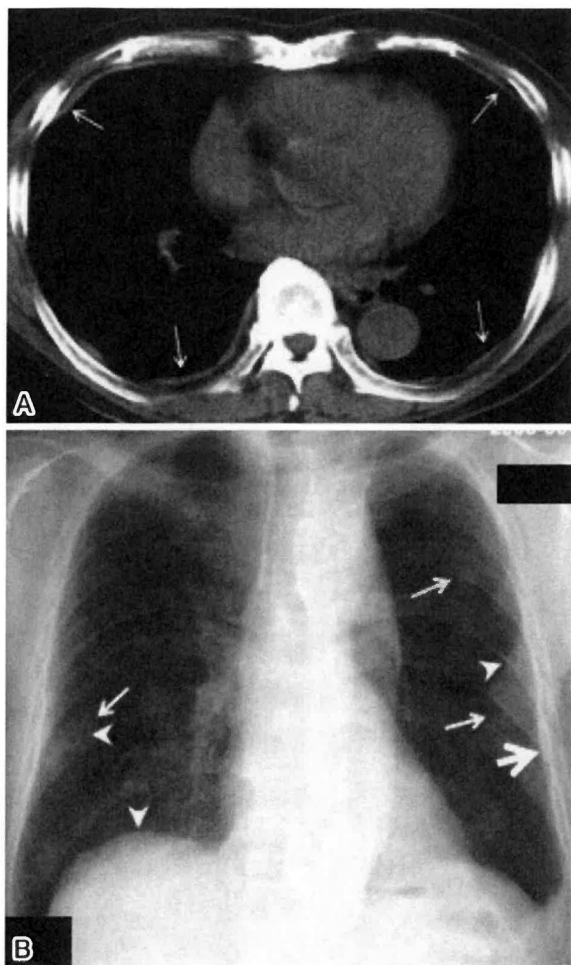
Examples of pleural plaques on (A) a chest CT (arrows indicate pleural plaques) and (B) a chest radiograph (arrows indicate face-on plaques, thick arrow indicates in-profile plaque, and arrowheads indicate calcified plaques)
